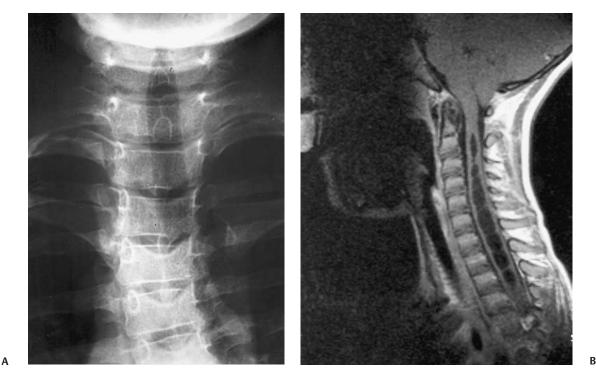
(A) PA view of the lower cervical/upper thoracic spine of a boy with a painful thoracic "idiopathic" scoliosis, showing the typical gross interpedicular widening of a syrinx. (B) Sagittal MRI scan of the same region, showing a very large syrinx.
